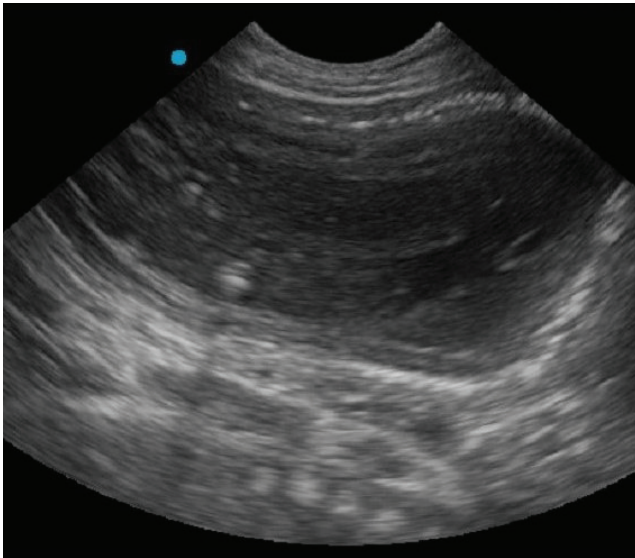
Transabdominal ultrasonographic image of fetal demise, note the hyperechoic foci around fetus (air shadowing), and fetus is poorly defined due to autolysis.
